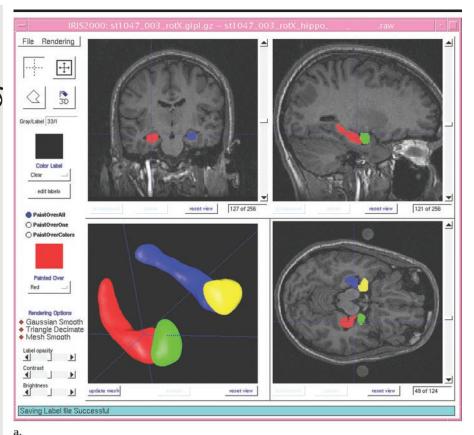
Three-dimensional model-based segmentation. Screenshot demonstrates elastic model-based segmentation of limbic structures, including amygdalae (green and yellow) and hippocampi (blue and red). (a) Segmentation is shown in three-dimensional surface rendering (bottom left) and two-dimensional overlay on T1-weighted MR images in three orthogonal planes (top left and right, bottom right). (b) Sagittal T1-weighted MR image demonstrates outline of hippocampus in green. (c) Hippocampus (yellow) and neighboring brain structures (blue, green, and red) are shown on three-dimensional volume rendering of the brain. (Images courtesy of Guido Gerig, PhD, University of North Carolina, Chapel Hill.)
